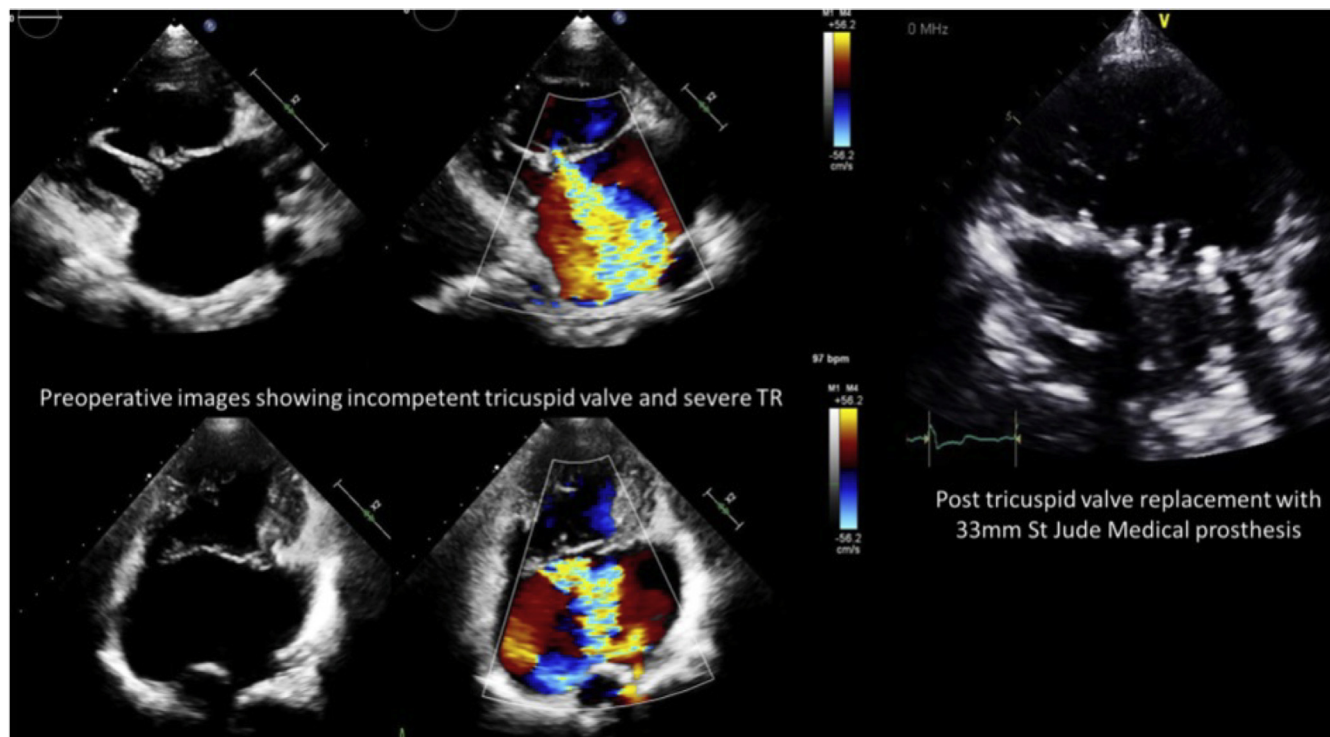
Echocardiographic images of case 2 pre- and post-tricuspid valve replacement. TR, tricuspid regurgitation.
